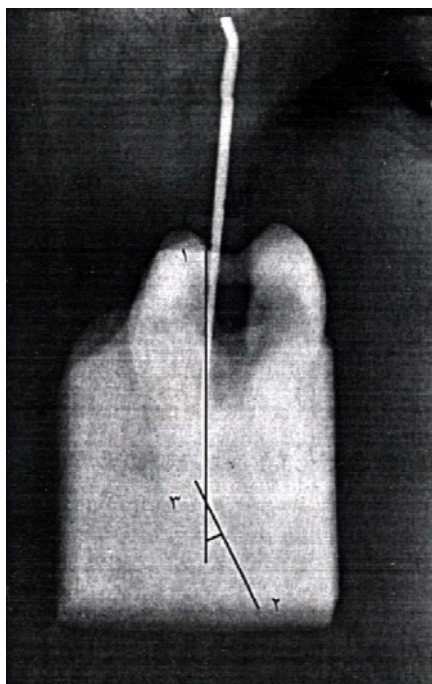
Digital radiograph of a sample with a file in place in a molar, mounted in a plaster block.
